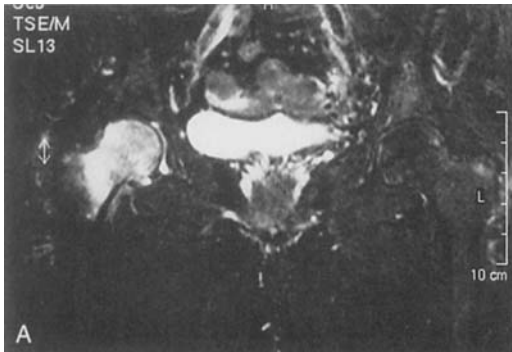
Coronal fat suppressed T2-weighted images and a radiograph of Patient 2. (A) Bone marrow edema and joint effusion are seen in the right femoral head and the intertrochanteric region, whereas (B) a plain radiograph is nondiagnostic. (C) Six months after core decompression, bone marrow edema has resolved completely (C).
